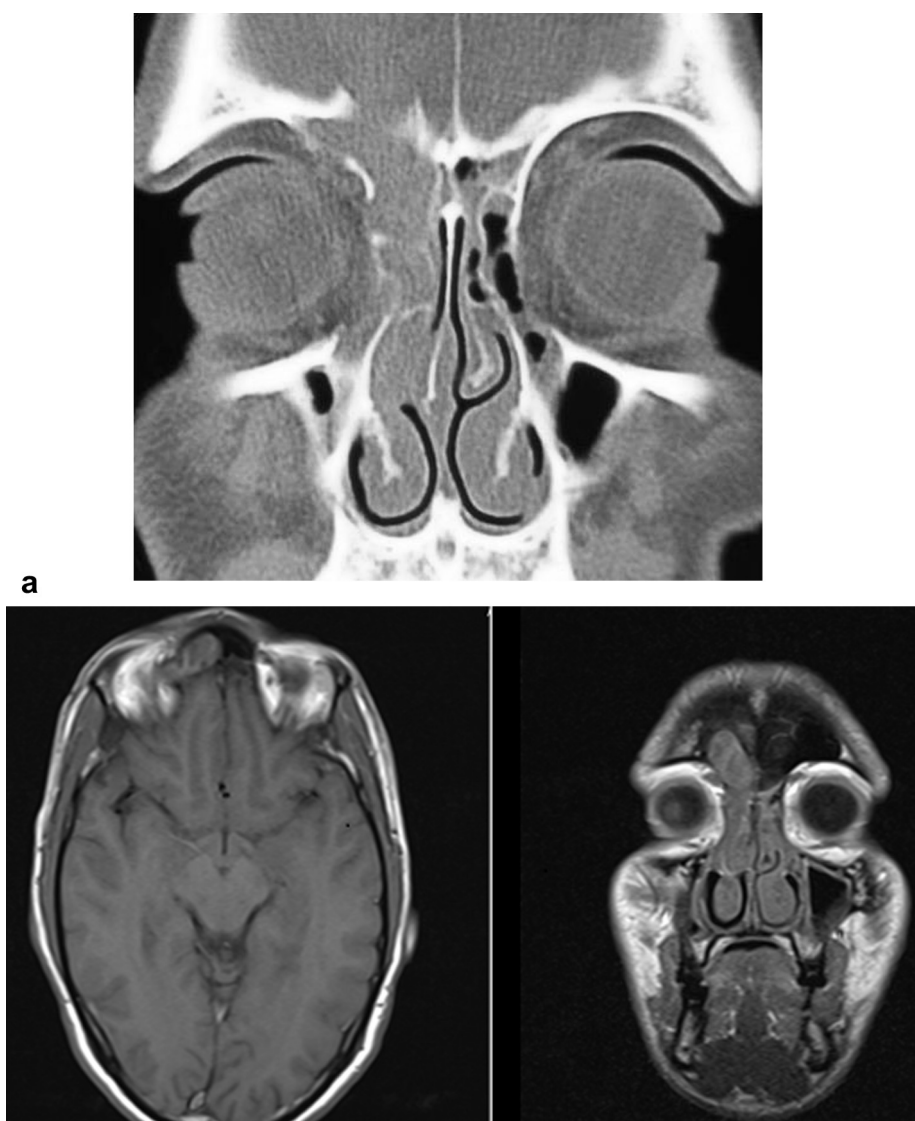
Coronal CT scan showing mass in right frontal recess with features suggestive of mucocele in frontal sinus eroding posterior table of frontal sinus. (a) Coronal and axial cuts of MRI PNS showing mass in right nasal cavity with extension to frontal recess and erosion of posterior table of frontal sinus.
